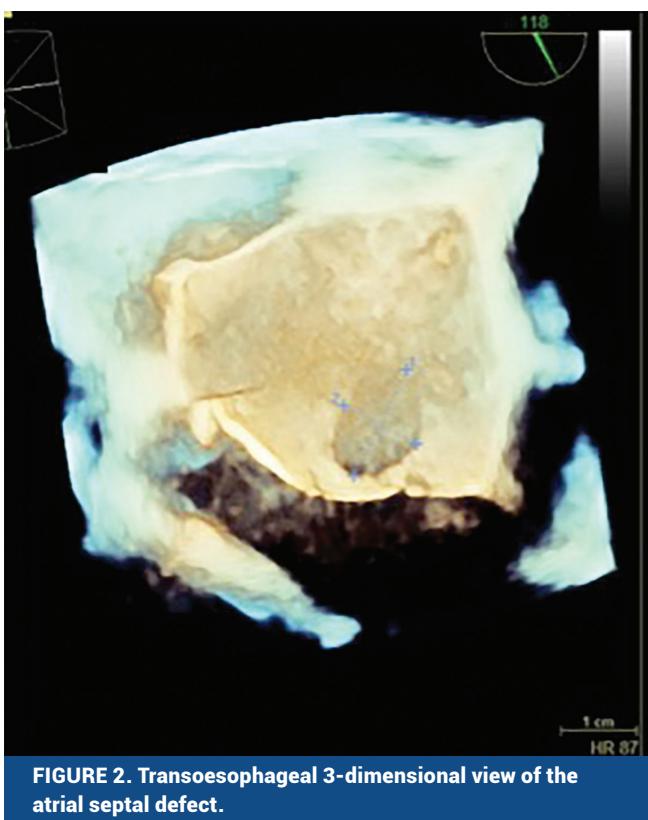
Transoesophageal 3-dimensional view of the atrial septal defect.
